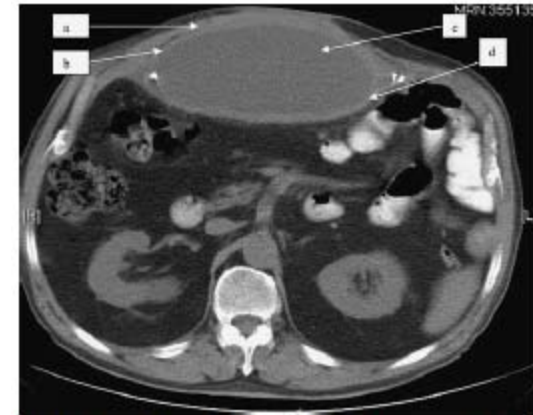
Sub facial placement of Surgisis Gold perforated mesh. This computed tomography (CT) scan clearly demonstrated the incorporation of the outer layers of the mesh. The un-incorporated inner layers of the mesh result in the seroma formation. *a* Fascia. *b* Superficial layer of Surgisis mesh in contact with peritoneum. *c* Inner layers of the fascia seroma. *d* Deep layer of the Surgisis mesh in contact with omentum.
